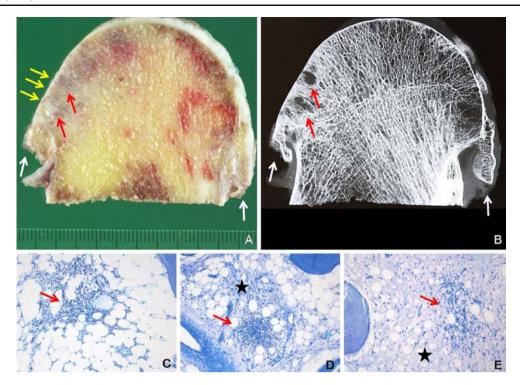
Control tissues. A central slice was cut in medial-lateral plane by means of a water-cooled diamond band coated saw. Macroscopically (a), femoral head with focal complete loss of hyaline cartilage (yellow arrows), initial formation of subchondral pseudocysts (red arrows), and osteophyte at the margins (blue arrows) were evident. Contact radiography (b) highlighted the osteolytic pseudocystic defects (red arrows) and marginal osteophyte formations (blue
